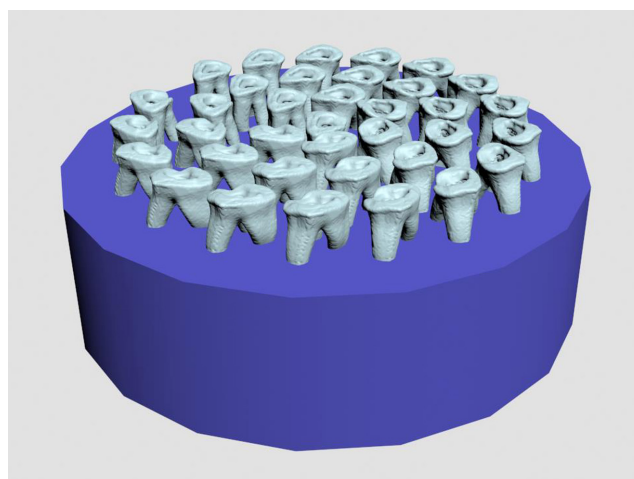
Images of a cylindrical base designed for cone-beam computed tomography imaging with printed roots.
